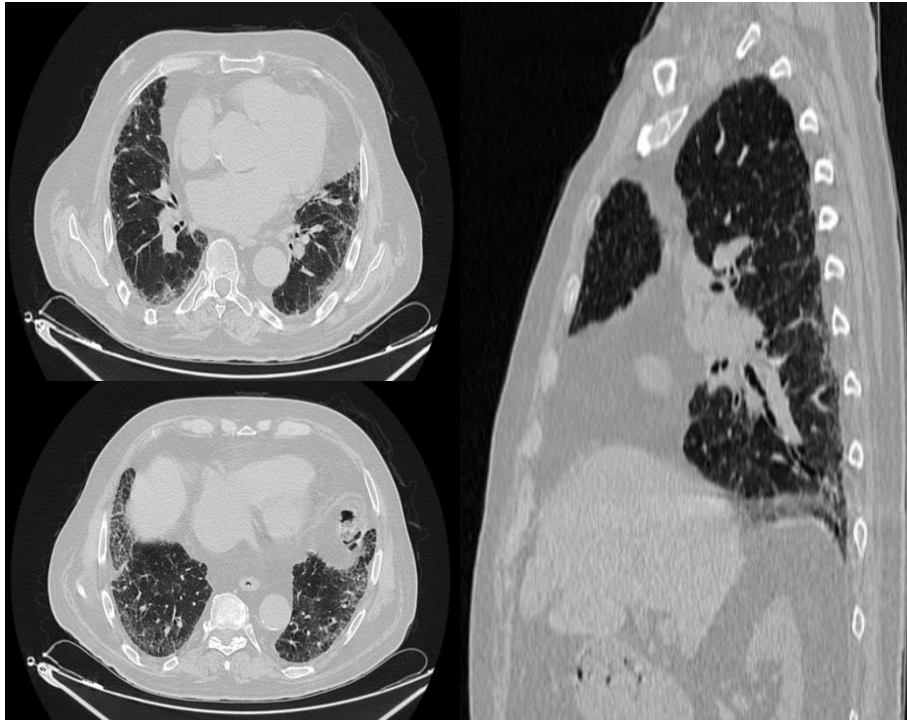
A 74-year-old patient was admitted for respiratory distress. Chest CT scan without contrast, axial and coronal slices; parenchymal window: multiple bilateral septal and non-septal reticulations, predominantly subpleural, associated with a few layers of honeycombing at the lung bases. Peripheral cystic lesions. Diagnosis: IPF.
